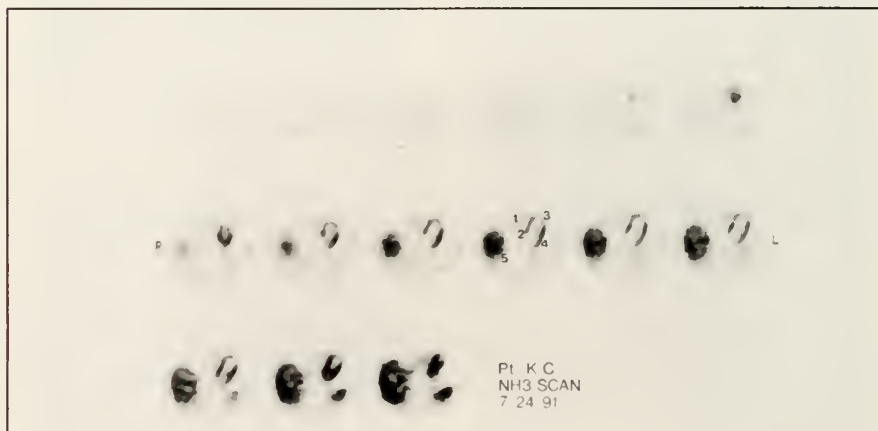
Tomographic sections of the heart are shown from a patient (KC) with previous anterior myocardial infarction. The scans depict myocardial blood flow as measured with ¹³NH₃. Note the clarity and anatomical detail of the images. An anteroapical defect is present and corresponds to the zone of infarction albeit with some residual flow (0.51 ml/min/g). Myocardial blood flow in the lateral wall (1.71) was within the range of normal but was reduced in the interventricular septum (0.73). The later finding is consistent with hibernating, viable myocardium in the region and was confirmed by imaging with ¹⁸FDG (fluorodeoxyglucose; Figure 1B). Abbreviations: 1=right ventricle; 2=interventricular septum; 3=anteroapical segment (left ventricle); 4=lateral wall (left ventricle); 5=liver
